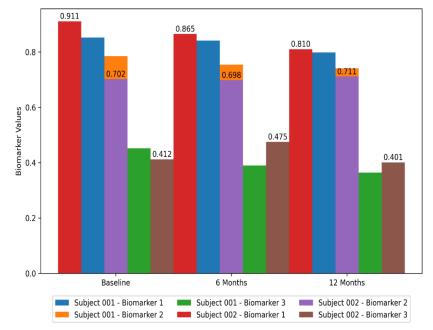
Representation of Structural MRI analysis
